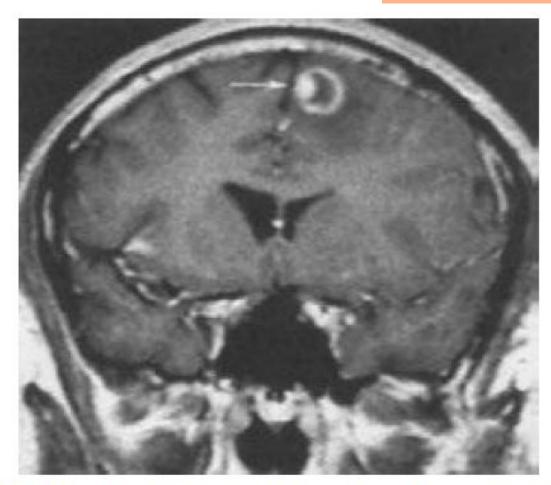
Central nervous system toxoplasmosis. A coronal postcontrast T1-weighted MRI scan demonstrates a peripheral enhancing lesion in the left frontal lobe, associated with an eccentric nodular area of enhancement (*arrow*); this so-called eccentric target sign is typical of toxoplasmosis.
